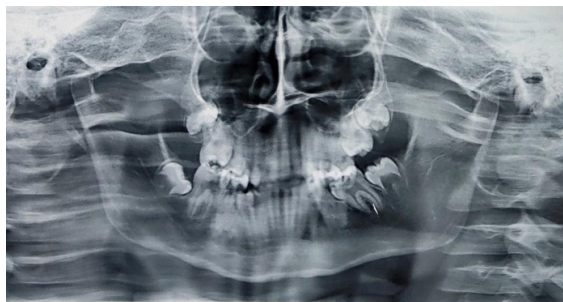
Panoramic radiograph showed normal development of dentition
